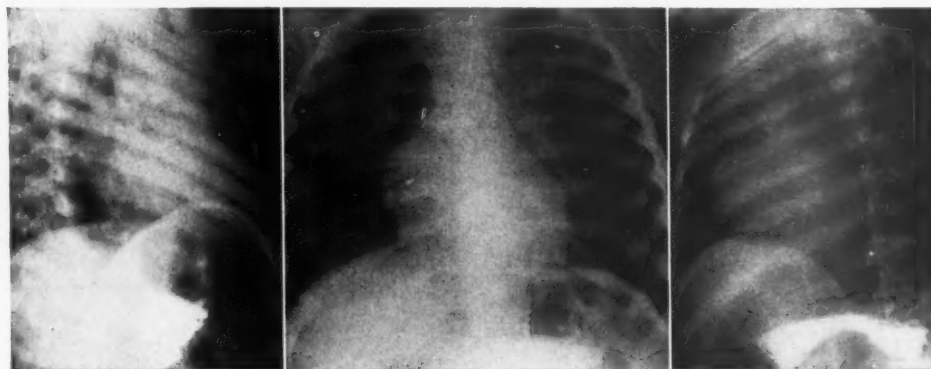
Preoperative roentgenograms of patient no. 2 with patent ductus arteriosus and pulmonic stenosis. There is slight cardiomegaly but pulmonary vascularity appears within normal limits. *Left*, right anterior oblique; *middle*, posteroanterior; *right*, left anterior oblique.
